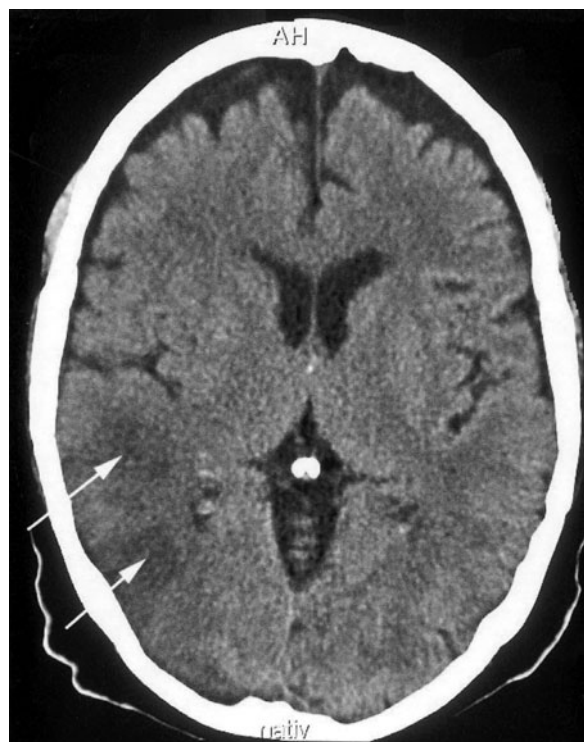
Computed tomography performed 2 days after surgery showing multiple focal ischemic lesions of the brain. Areas of demarcated necrosis can be seen (arrows) in the temporo-occipital junction of the right hemispheres. The damage was attributed to a retrograde perfusion of the aorta leading to dislodgment and embolization to the brain of mural thrombi.
